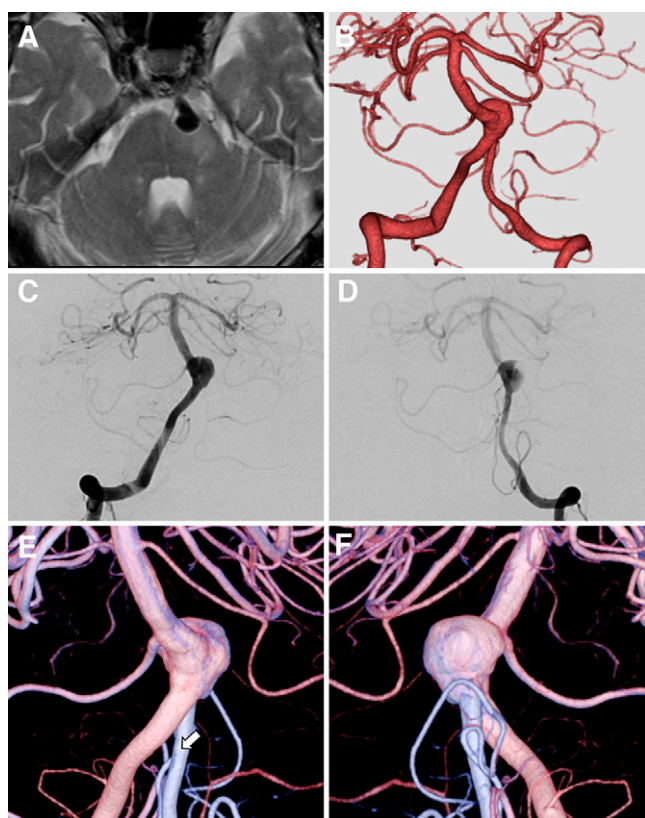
Axial T2-weighted MRI (A) showing an aneurysm embedded in the brainstem with perifocal edema. The VBJ complex aneurysm was identified using CTA (B). Anteroposterior right (C) and left (D) VA digital subtraction angiography (DSA). Anteroposterior (E) and posteroanterior (F) three-dimensional rotational angiography fusion images. Arrows indicate branching of the ASA.
